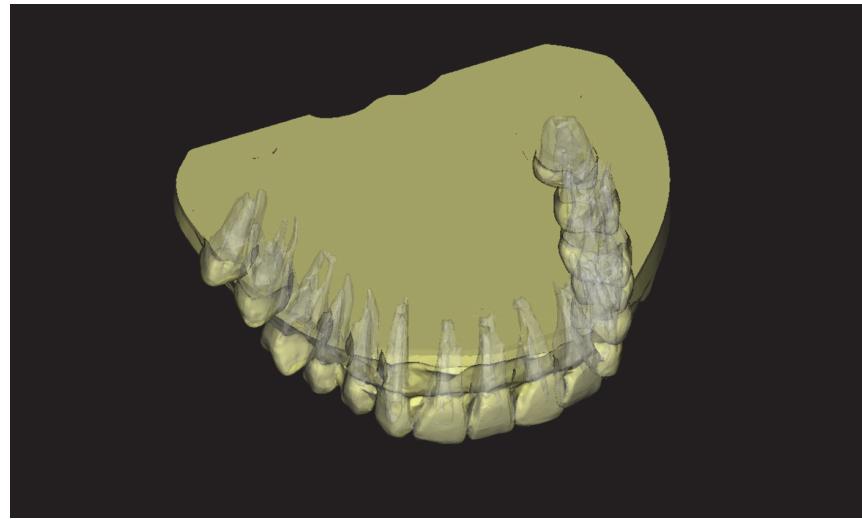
The integrated 3D images between the dental model and CT digital data (yellow: dental model, white: CT).
